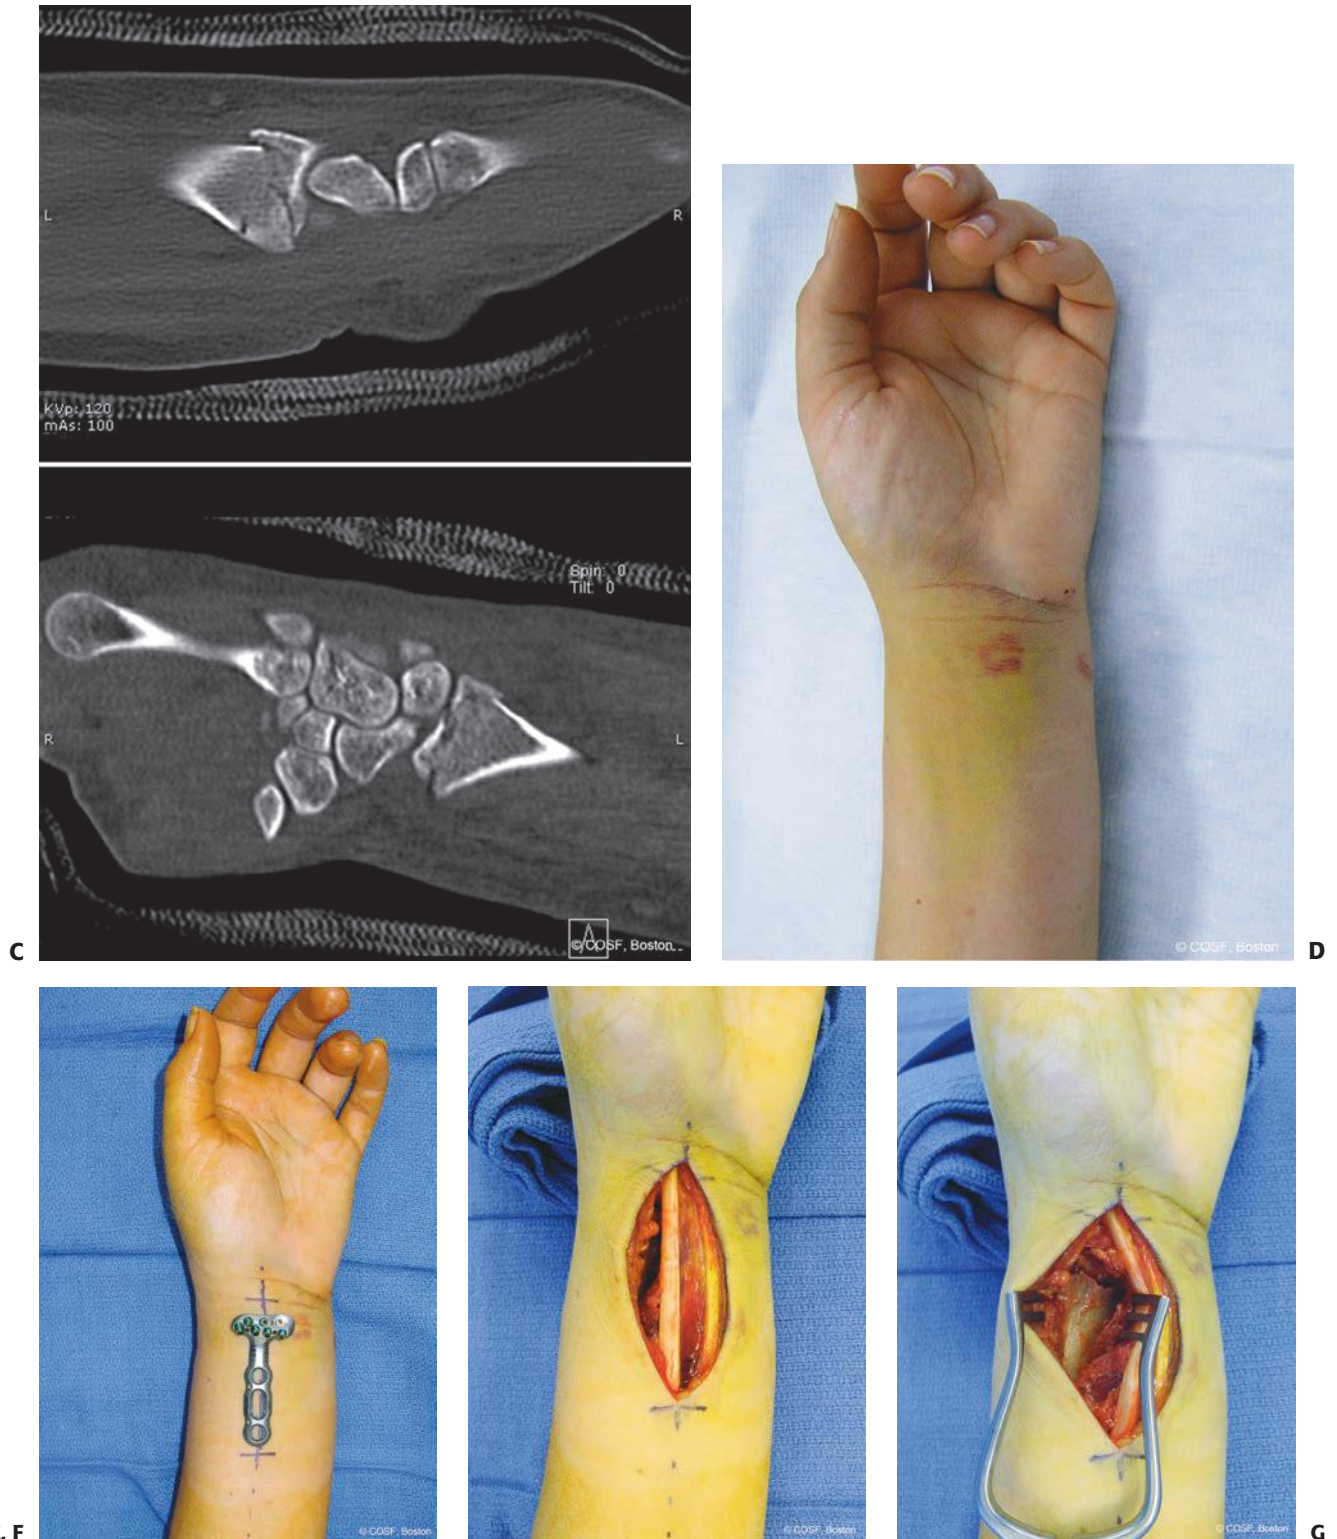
(continued) C: Representative postreduction CT scan images revealing joint displacement. D: Clinical appearance after decreased swelling over 5 days preoperatively. E: Planned plate for fracture fragment-specific volar fixation. F: Volar approach via FCR tendon sheath. G: Exposed fracture site with reduction.
